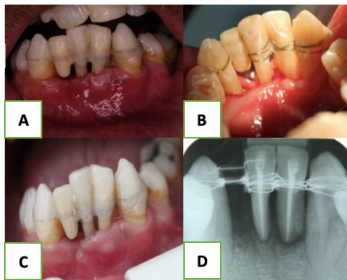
(A) Post-operative view after 2 weeks. (B) Post-operative view after 3 months (buccal) and (C) lingual area. (D) Post-operative radiograph after 3 months.
